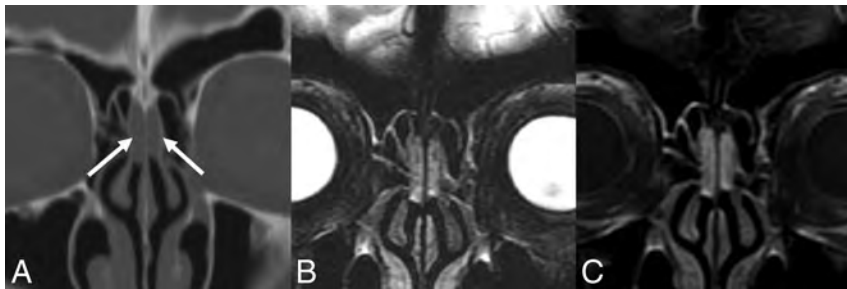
REAH. A, Coronal noncontrast CT shows mildly expansile soft tissue in the bilateral olfactory clefts without adjacent bony erosion or destruction (*white arrows*). Coronal T2 fat-saturated (B) and coronal T1 postcontrast, fat-saturated (C) MR images in the same patient show the lesions to be heterogeneous and hyperintense to the cortex on T2WI and enhancing.
